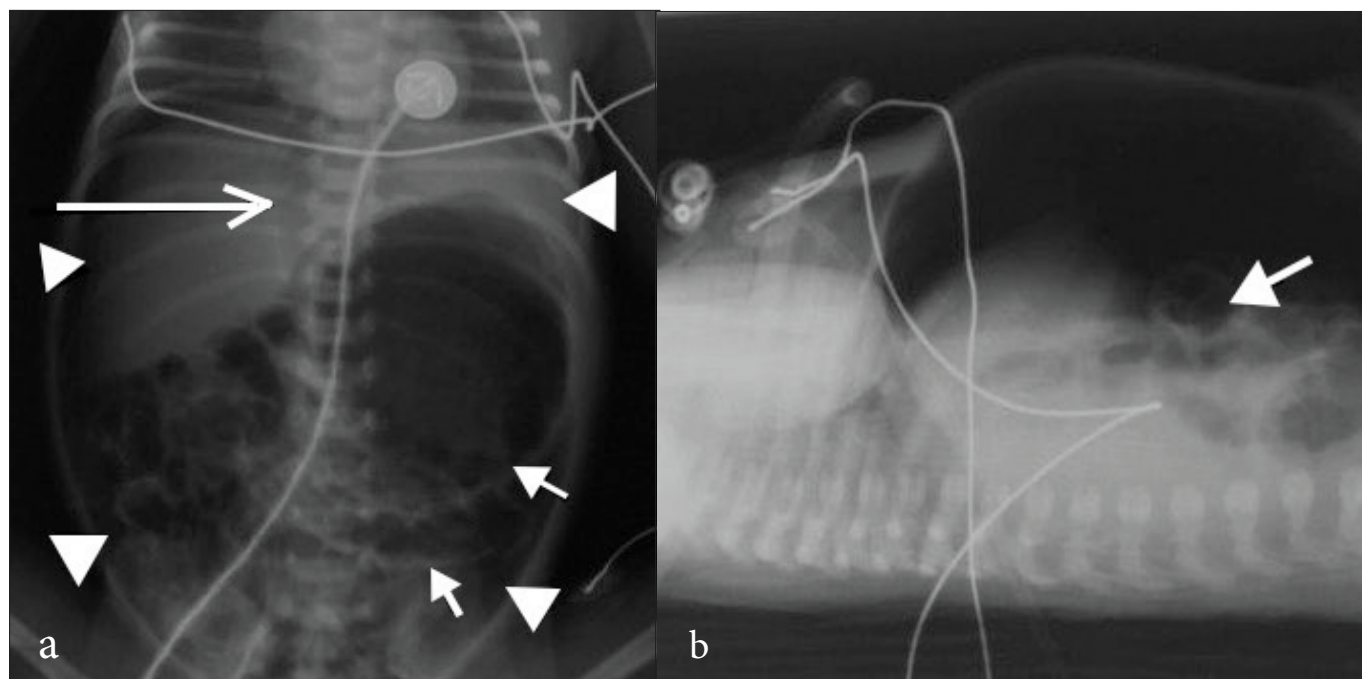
(a) Supine abdominal radiograph demonstrating Rigler's sign (closed arrows) and the football sign (arrow heads) in a patient with iatrogenic gastric perforation. Rigler's sign is the visualisation of the inner and outer bowel wall owing to pneumoperitoneum, also known as the double-wall sign. The football sign is described as an oval radiolucency owing to pneumoperitoneum that resembles an American football. The vertical opacity of the falciform ligament (open arrow) represents the laces, and the remaining abdomen represents the remaining portion of an American football. (b) The lateral decubitus view confirms the pneumoperitoneum. Note Rigler's sign (closed arrow).
